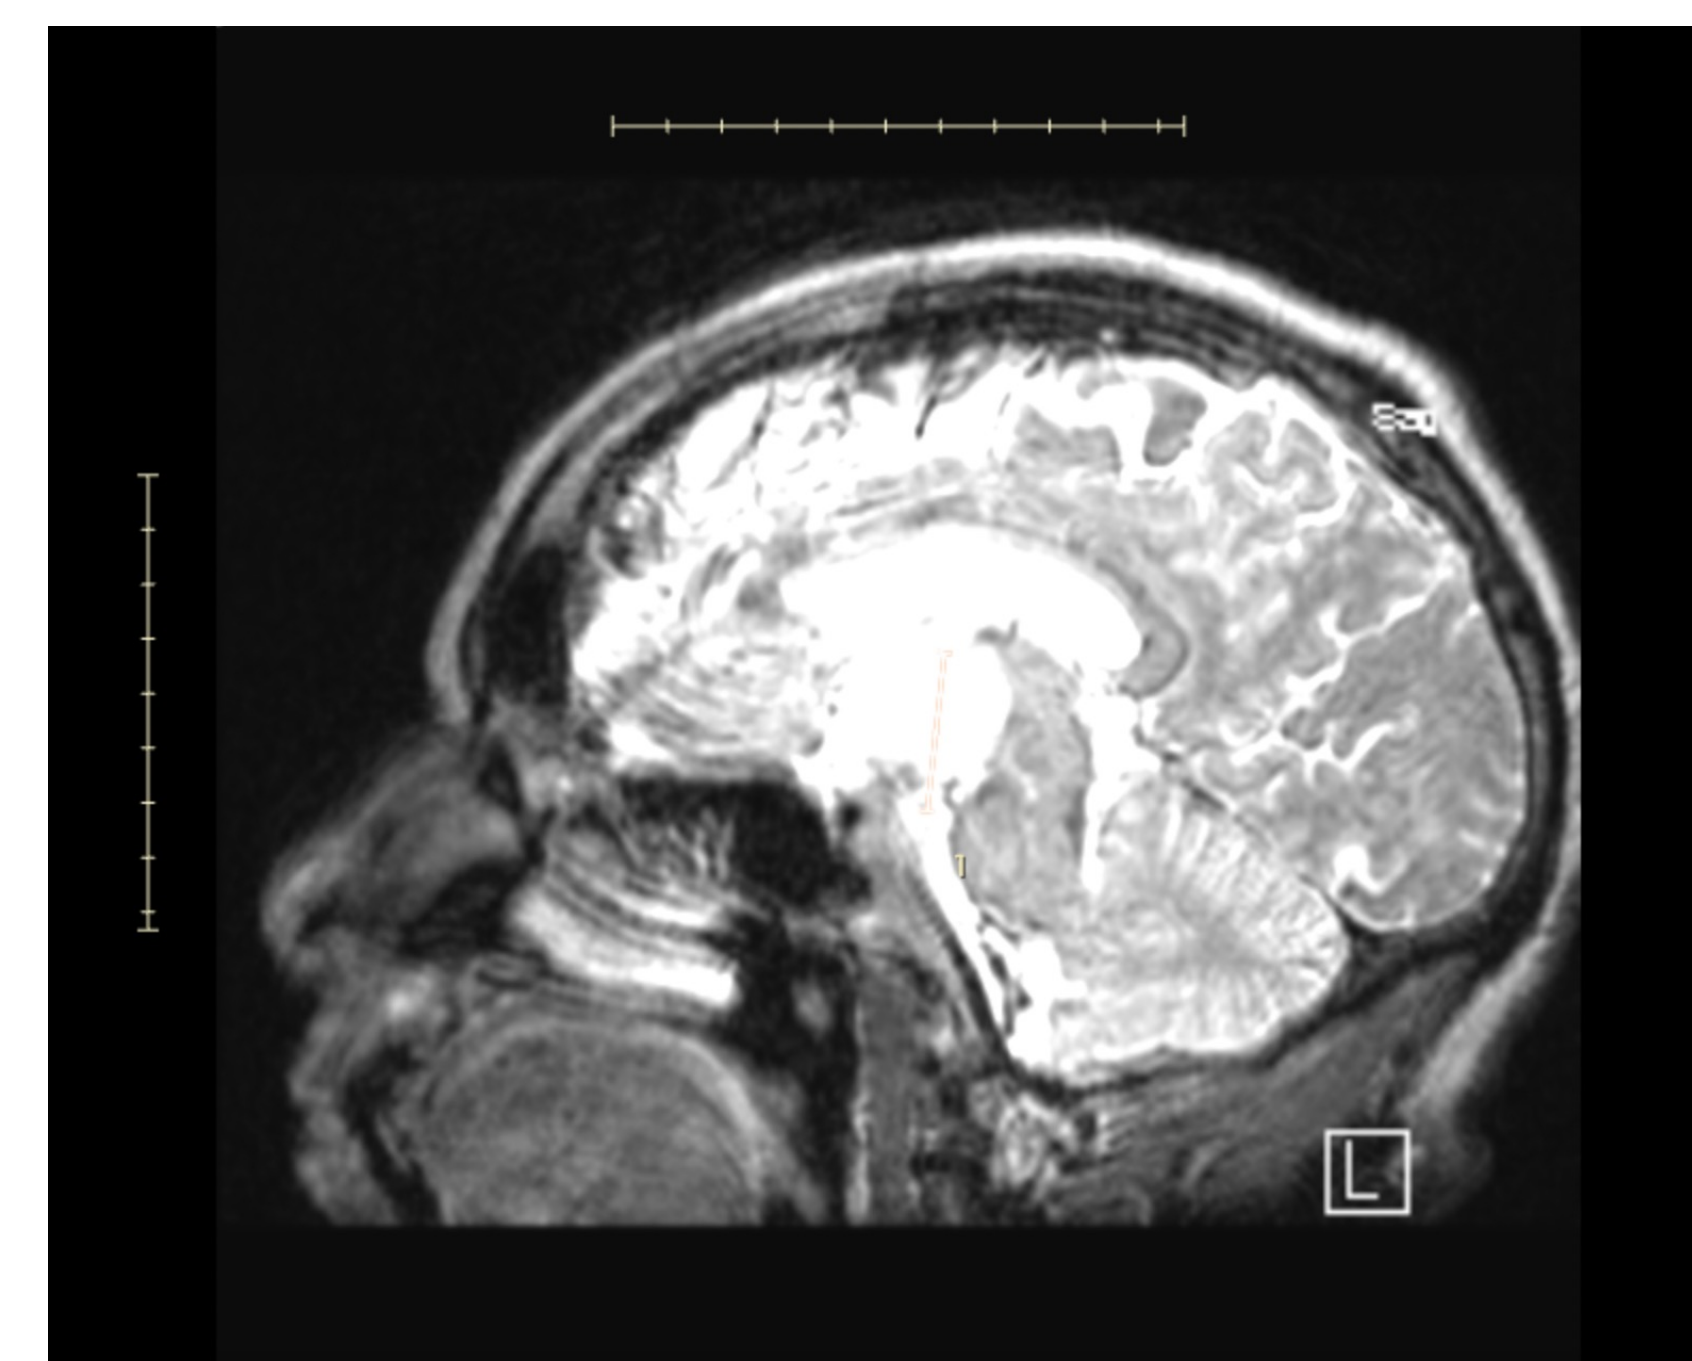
Sagittal brain MRI depicting cholesterol granuloma
